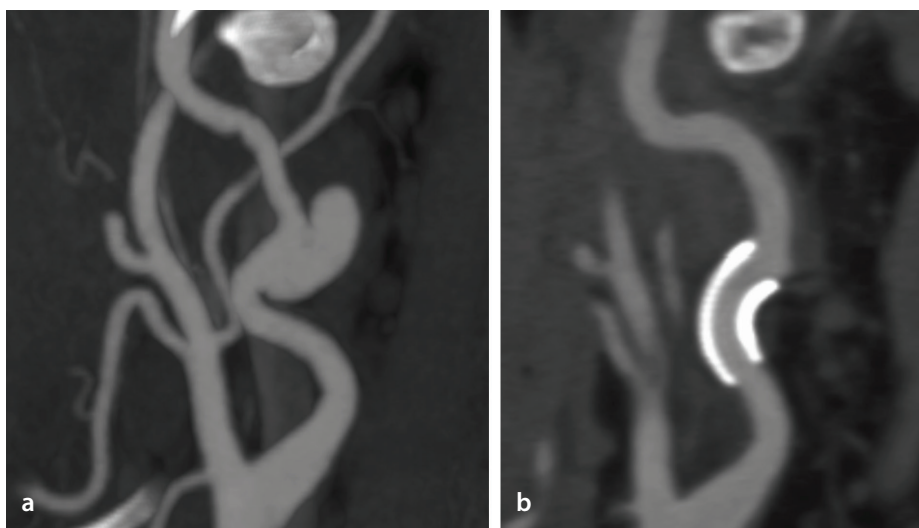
Patient 2: Sausage-shaped, presumably dissecting aneurysm located in the left cervical internal carotid artery (ICA). (a) Computed tomography (CT) angiography shows an aneurysm located in the low cervical ICA. (b) One-year control CT angiography confirms occlusion of the aneurysm.
